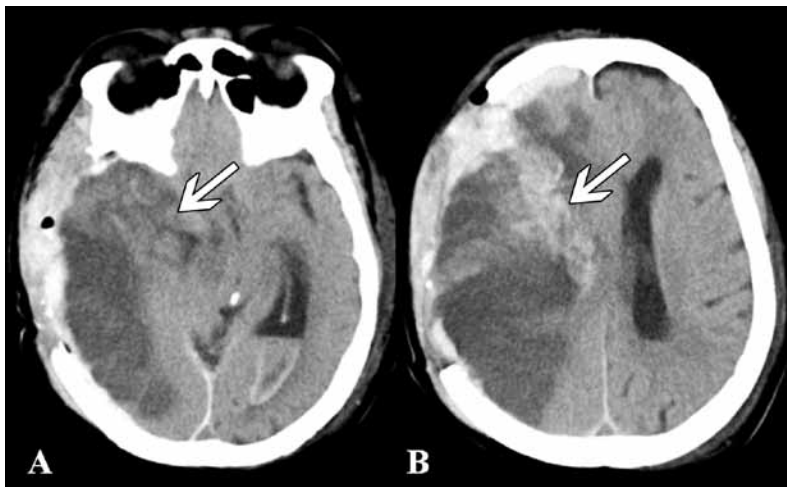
Postoperative CT scans (A & B) showed a decompressive craniectomy with almost no secondary intracerebral hemorrhage (arrows).
